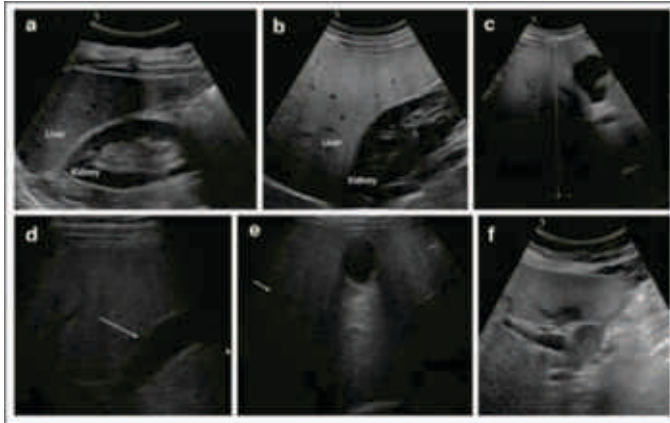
Appearances of fatty change liver on ultrasonography
